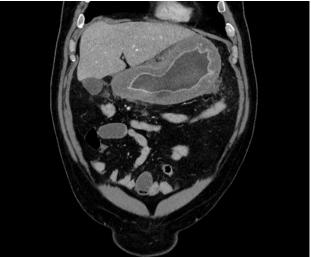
Abdominal-pelvic CT scan documenting markedly diffuse parietal thickening of the stomach with increased mucosal enhancement and densification of peri gastric fat and decreased homogeneous enhancement of the submucosal and muscular layers.
